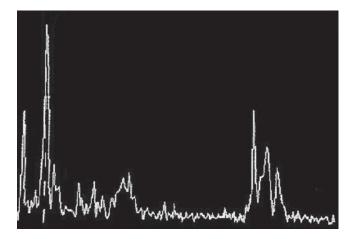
The A-mode of ultrasound consists of a one-dimensional ultrasound image displayed as a series of vertical peaks corresponding to the depth of structures at which the ultrasound encounters different tissues.
